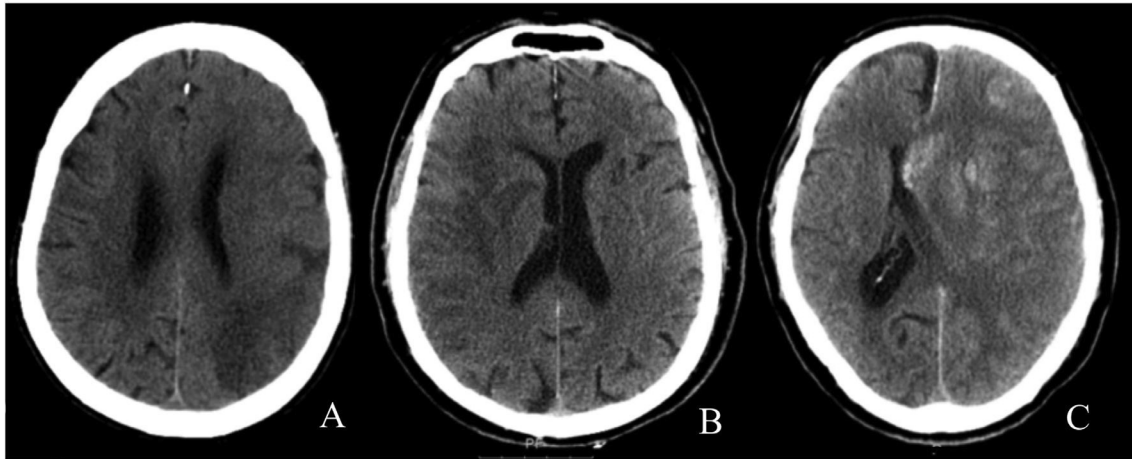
Non contrast head CT of patients with cerebral edema at 24h post thrombectomy (A: COED 1, B: COED 2 and C:COED 3).
